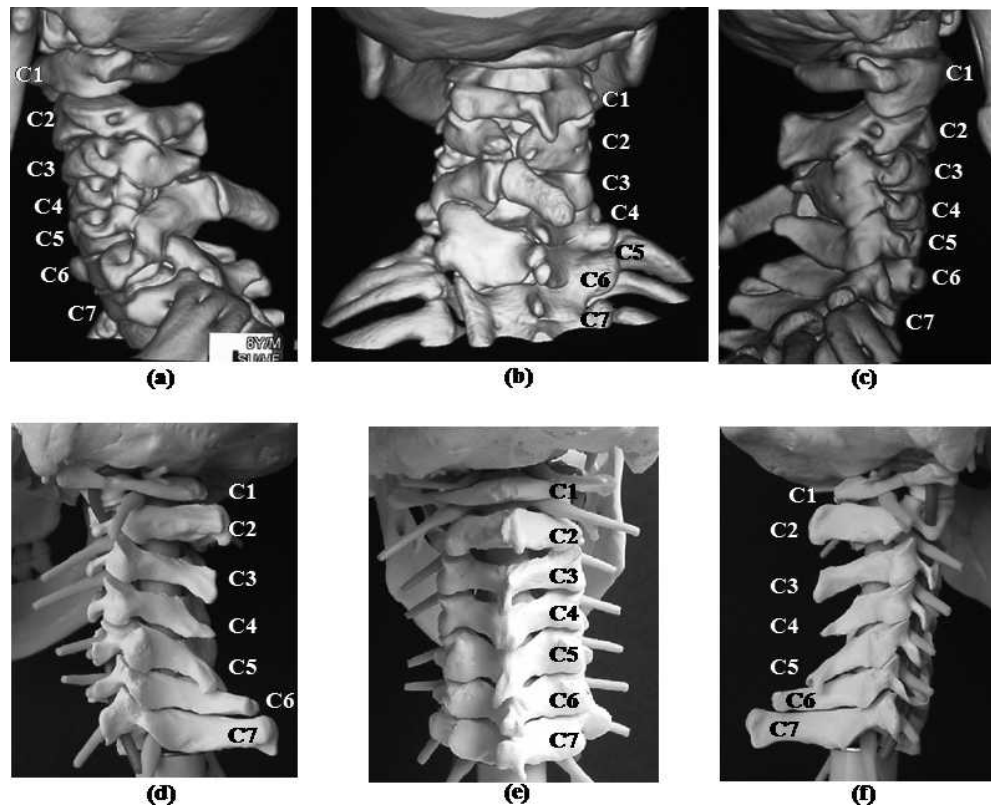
Three-dimensional reconstructions from computed tomography scan of the cervical vertebrae for the patient: (a) left; (b) posterior; (c) right. Anatomical model of normal cervical vertebrae: (d) left; (e) posterior; (f) right. C1–C7 indicates first through seventh cervical vertebrae.
